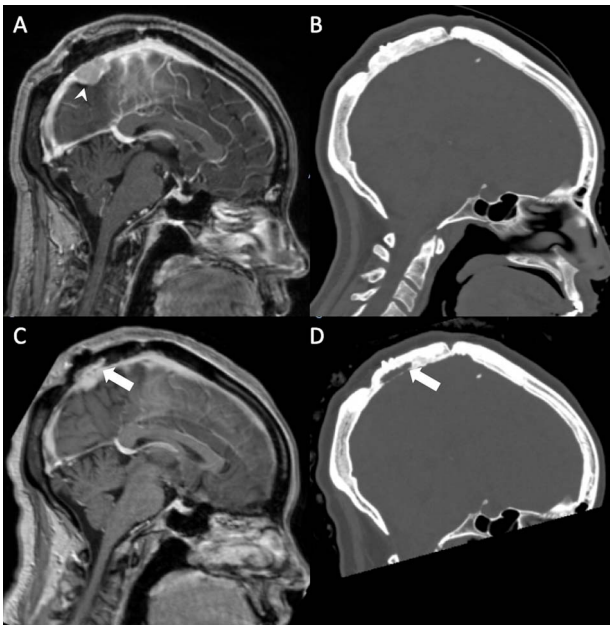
Case 2 prior to and at initial presentation of osteolytic lesion; (A) T1 post-contrast MRI sagittal slice obtained in 2017 at the time of SRS showing the initial meningeoma recurrence (denoted by arrowhead) and (B) comparable head CT sagittal slice windowed for bone at that same timepoint; (C) T1 post-contrast MRI sagittal slice obtained at the time of development of an enhancing lesion involving bone at 1-year post-SRS (denoted by arrow) and (D) comparable head CT sagittal slice obtained at the that same timepoint revealing the lytic bone lesion at this site (denoted by arrow).
